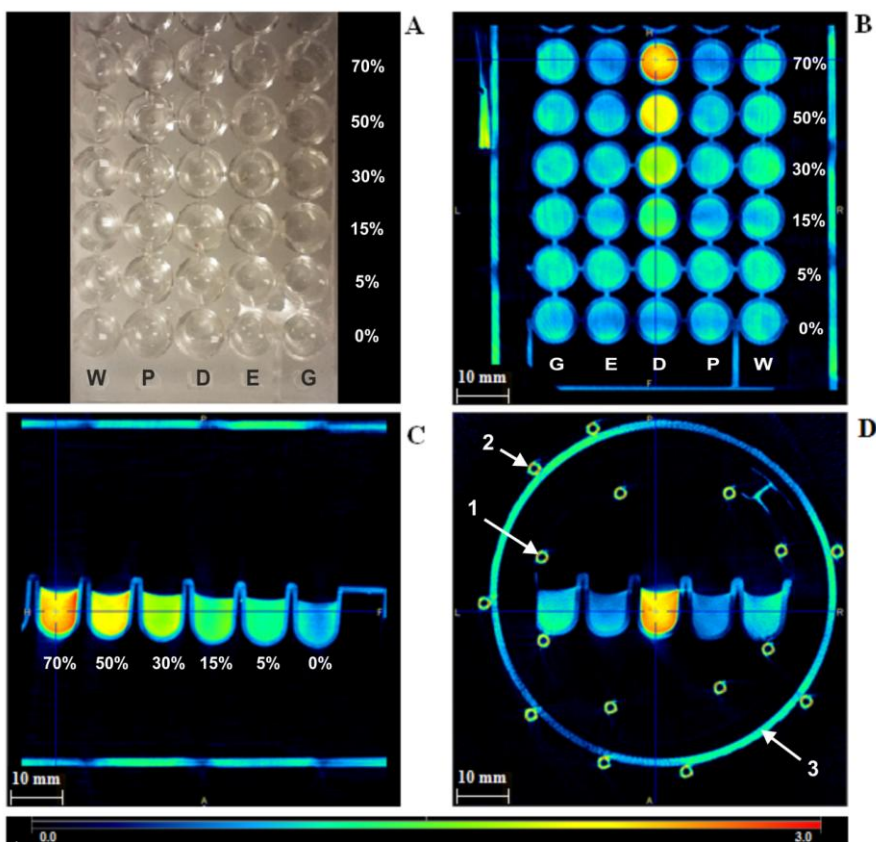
CT image of the three orthogonal views of different CPAs in several concentrations in a 9x5-well microplate, at 20 °C. The CT image uses the cold scale and a spatial resolution is 200 μm . The solutions correspond to water (W), 1,2-propanediol (P), dimethyl sulfoxide (D), ethylene glycol (E) and glycerol (G)
